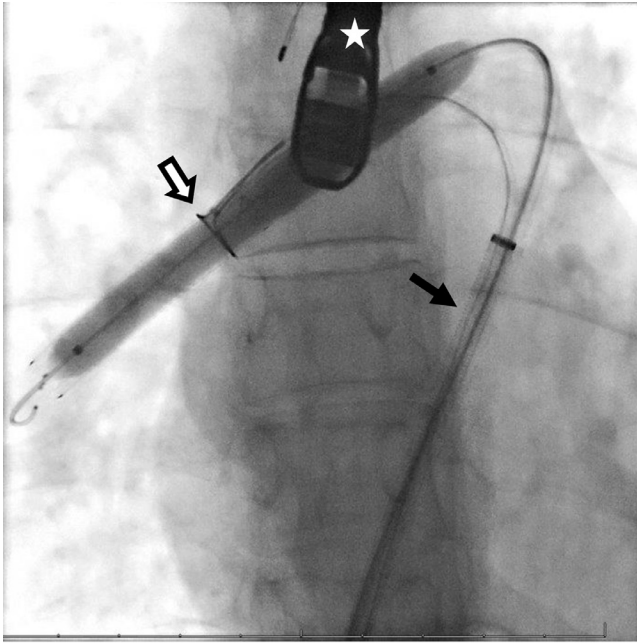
(A) – Procedural fluoroscopic image demonstrating a 10 x 8 cm balloon inflated in the migrated stent over a 0.035 inch Rosen wire, with a 15 mm ONEsnare over the stent and balloon (white arrow). Transesophageal echocardiography probe (white star) is seen projecting over the stent. A 12 French sheath is positioned in the main pulmonary artery (black arrow). (B) Intraprocedural transesophageal echocardiography image demonstrating the stent with an indentation proximally where the snare has been tightened over the stent/balloon complex (white arrow).
